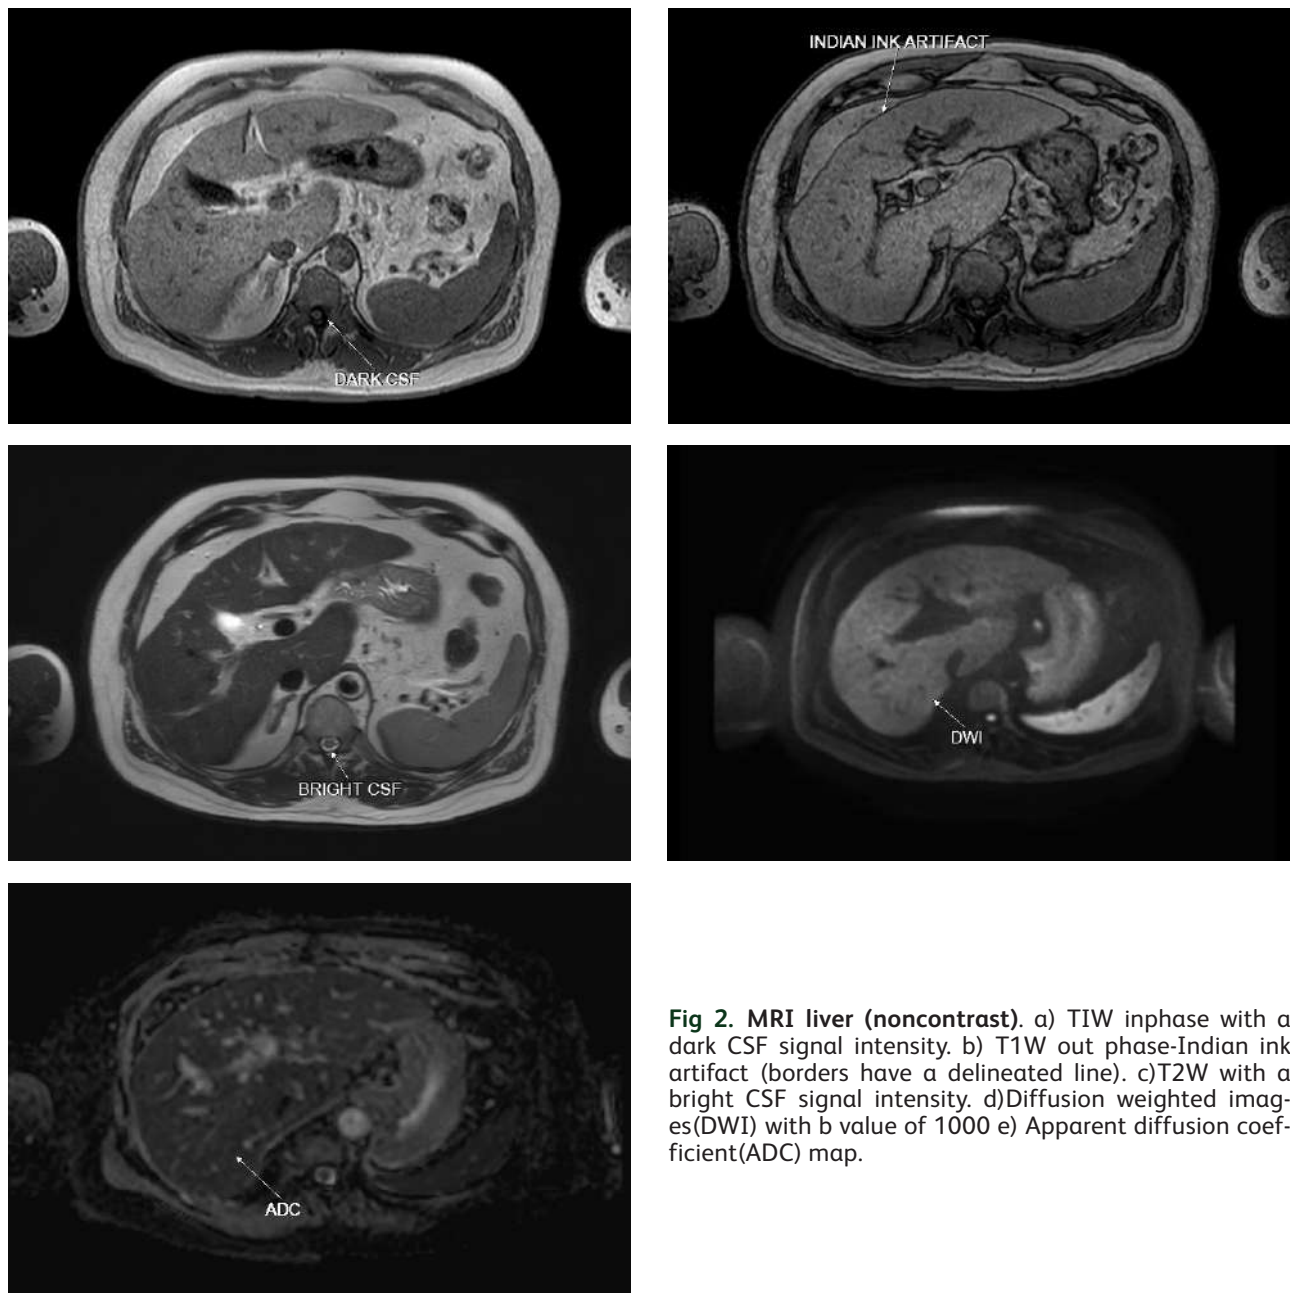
MRI liver (noncontrast). a) TIW inphase with a dark CSF signal intensity. b) T1W out phase-Indian ink artifact (borders have a delineated line). c)T2W with a bright CSF signal intensity. d)Diffusion weighted images(DWI) with b value of 1000 e) Apparent diffusion coefficient(ADC) map.
